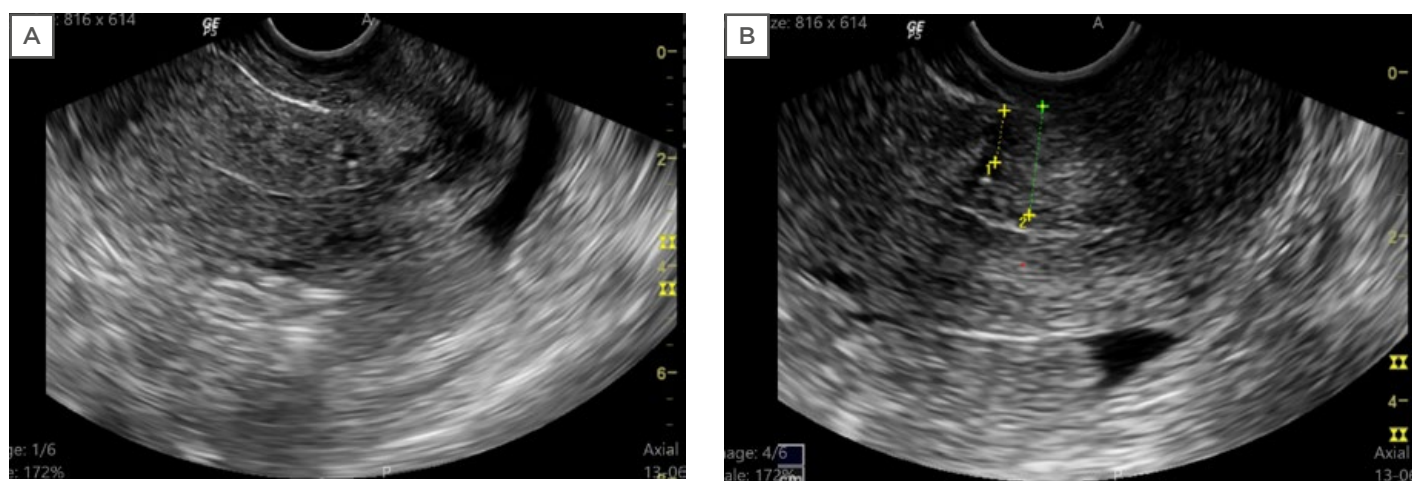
Imaging scans from a single patient. A) Transvaginal sonography showing the uterus in longitudinal section with thin endometrium and normal myometrium; B) saline hysterosalpingography showing the 'niche' with callipers marking the thickness of the residual myometrium (1) and adjacent myometrium (2).
